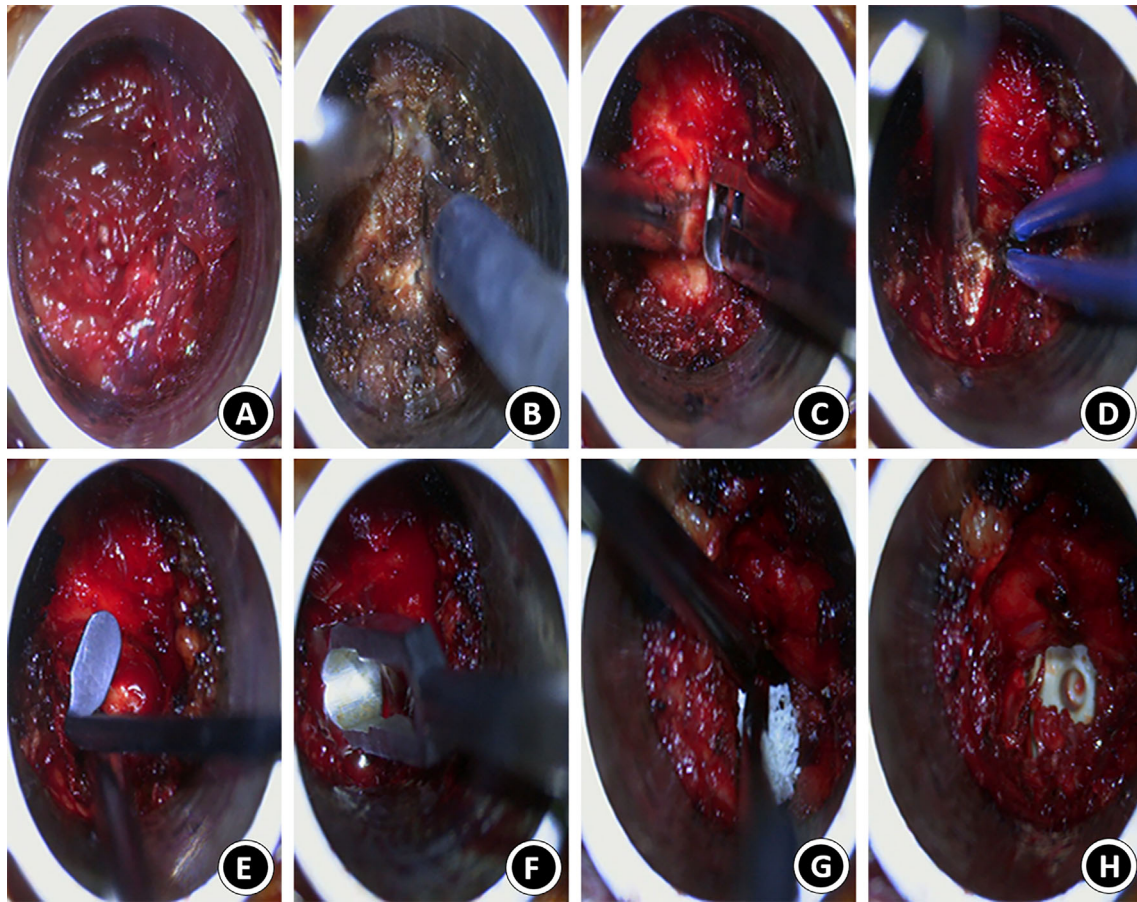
(A) the working channel was established; (B, C) facetectomy was performed with ultrasound bone scalpel and Kerrison rongeurs; (D) bipolar coagulation was used to achieve hemostasis; (E) a micro-hook was applied to verify the decompression of neural structures; (F) cartilage endplate was excised; (G) bone grafting was performed after discectomy; (H) the interbody cage was placed into the intervertebral space
